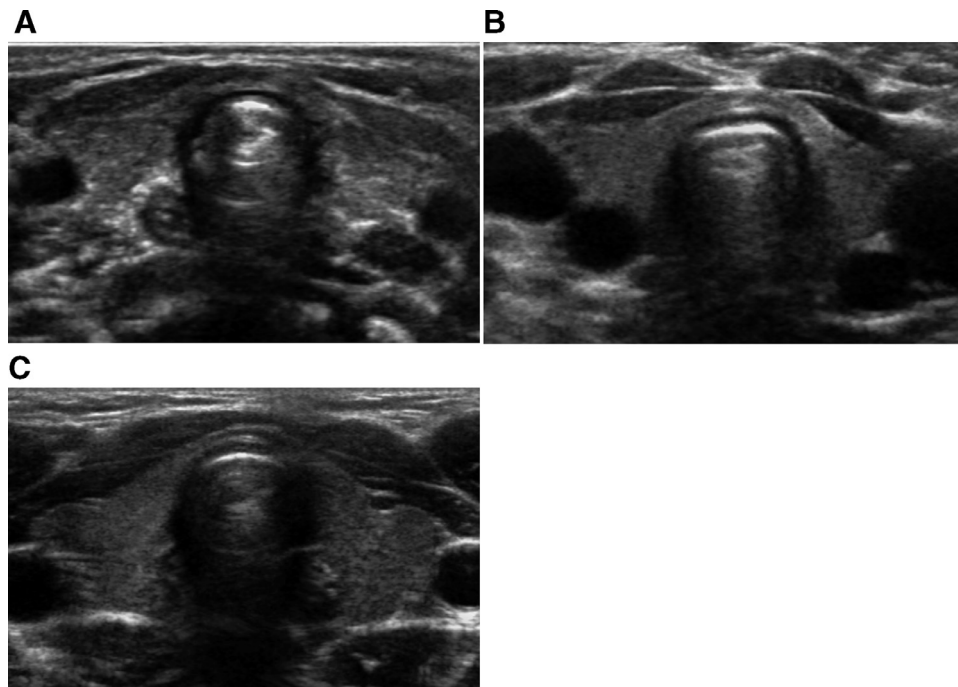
Transverse gray scale ultrasound images of normal thyroid glands show similar appearances in children of different ages. A. One-month-old boy. B. One-year-old girl. C. 10-year-old girl.
